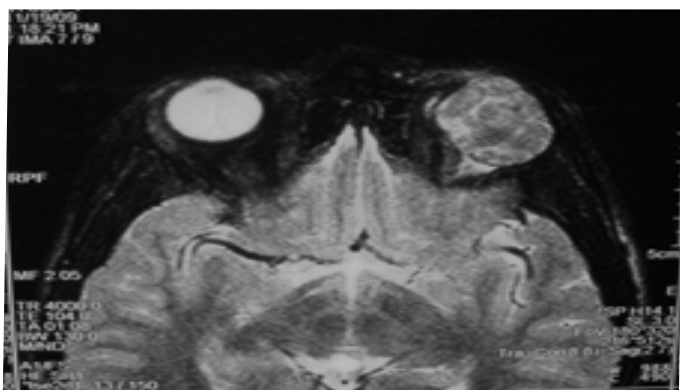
MRI ,T2 Axial image showing hyperintense lesion in the superolateral aspect with of the orbit causing proptosis
